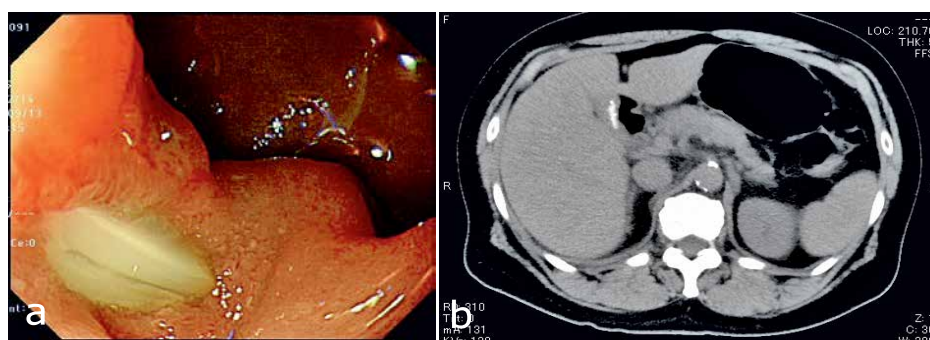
A screening esophagogastroduodenoscopy (EGD) revealed Hem-o-Lok clip appearance at the inferior wall of the first part of the duodenum; duodenal erosions and edema are observed around the Hem-o-Lok clip (a). Abdominal CT reveals that the Hem-o-Lok clip has migrated into the duodenal bulb (b).
